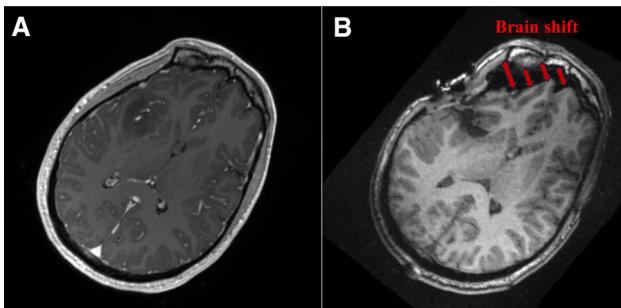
a Preoperative MRI. b Intraoperative MRI after brain shift
